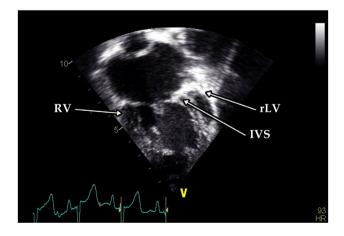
Apical four-chamber view. Abbreviations: IVS, interventricular septum; RV, right ventricle; rLV, rudimentary left ventricle
